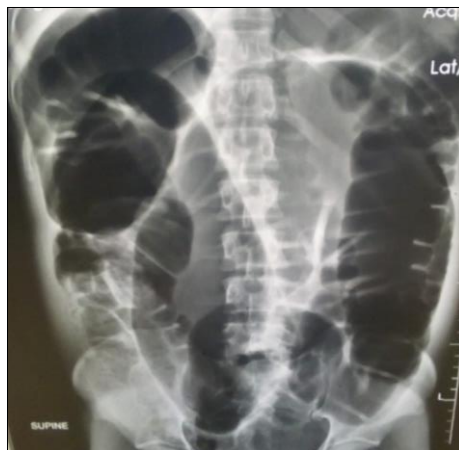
A plane abdominal x-ray showing dilated and gaseous large bowel with a typical coffee bean sign
